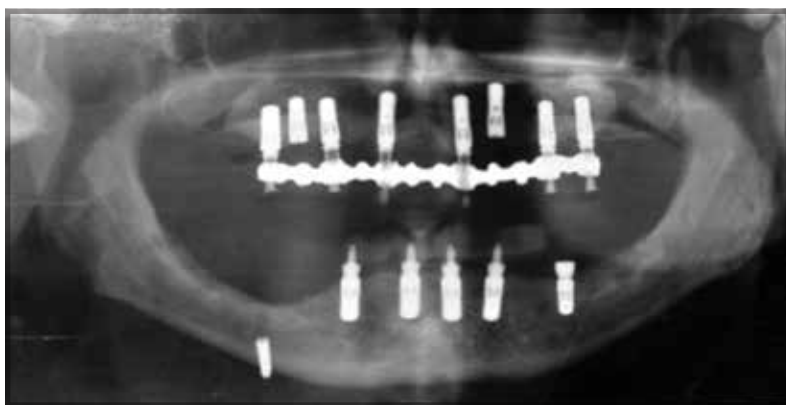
Case 4. Panoramic radiograph showing the implant in the submandibular space.
